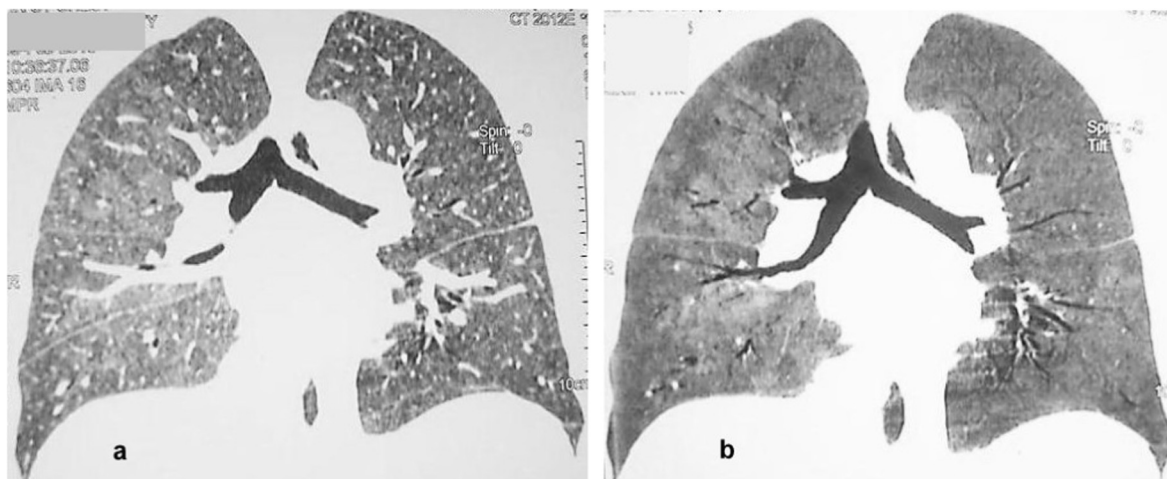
(a–e): A 55-year-old female patient with IP. Coronal HRCT images (a, b) show bilateral predominantly basal ground glass opacities and bronchial wall thickening. MinIP images (c, d, e) show better visualization of the ground glass opacities, as well as mild traction bronchiectasis within denoting fibrosis.
